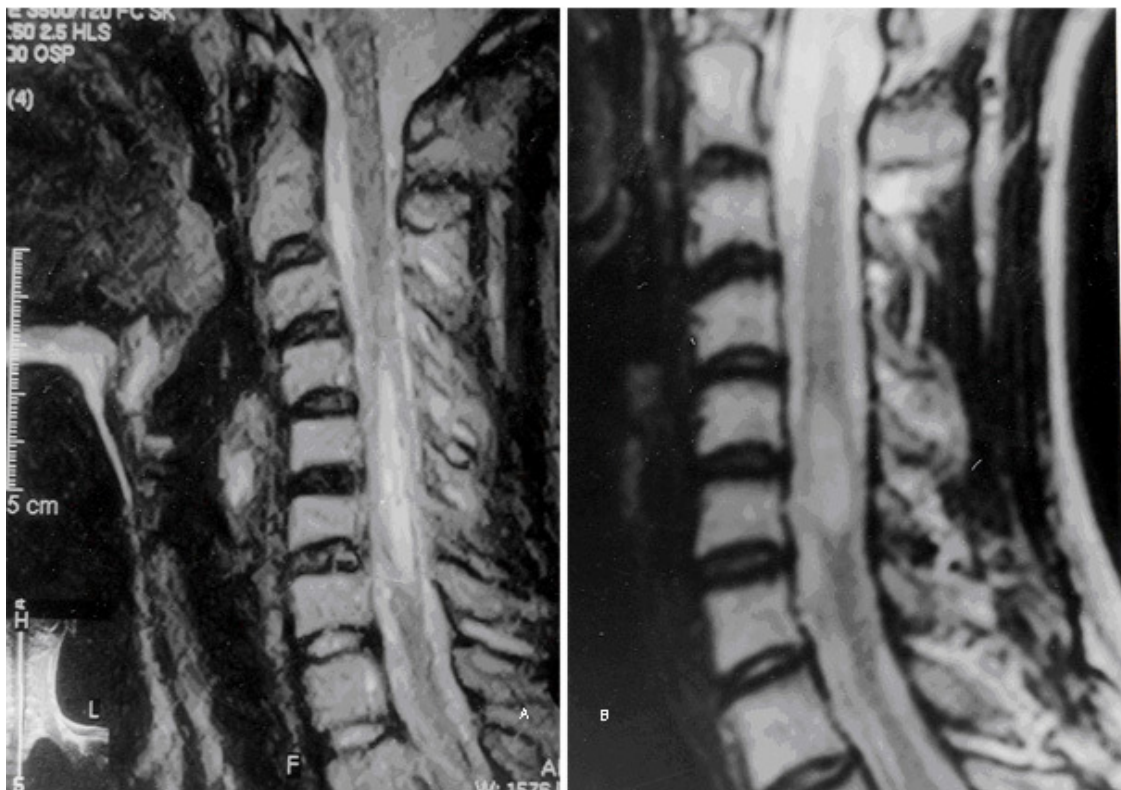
A woman born in 1953, a strict vegetarian, presented with spastic paraparesis and proprioceptive sensory impairment due to LETM in the posterior columns due to cyacobolamin deficiency. CSF was normal. Brain MRI normal.
